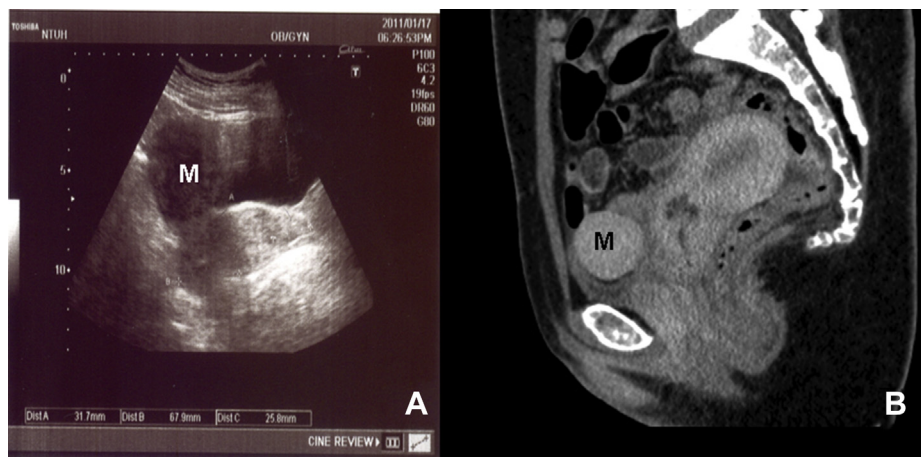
(A) The preoperative transabdominal sonography image shows one pelvic mass, which is suspected to be a uterine myoma. (B) Computed tomography shows a homogeneous enhanced mass that is suspected to be an exophytic uterine myoma with a stalk. M = myoma.
